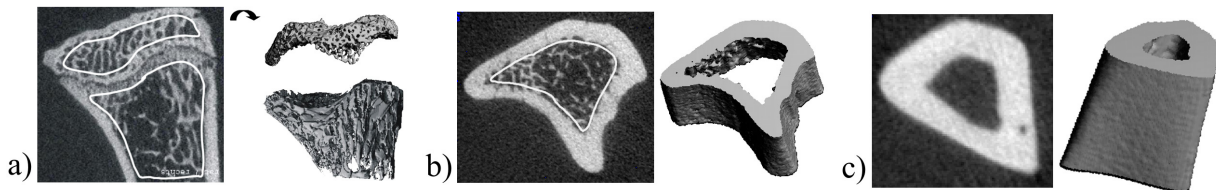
CT-scan of a) proximal metaphysis showing hand-drawn contours of the metaphyseal and epiphyseal trabecular bone b) proximal metaphysis showing hand-drawn contours of metaphyseal, cortical bone c) diaphyseal, cortical bone.
